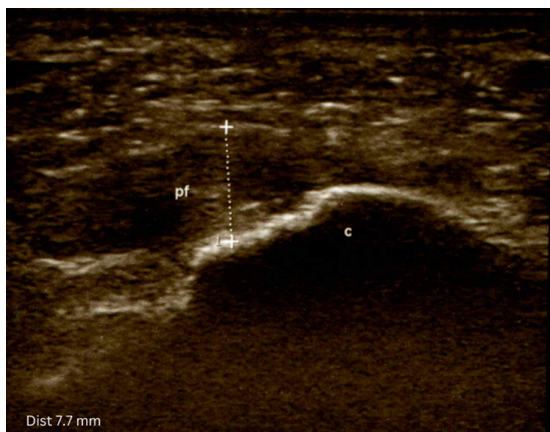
Longitudinal ultrasound showing increased thickness of left plantar fascia. PF, plantar fascia; c, calcaneus
